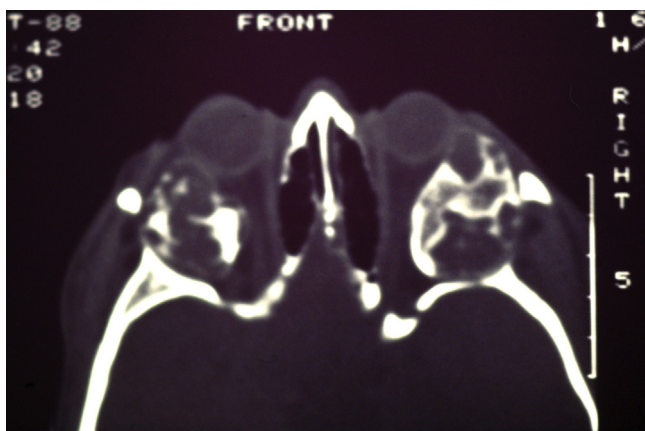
Preoperative axial CT scan demonstrating orbital involvement and proptosis of the globes.
